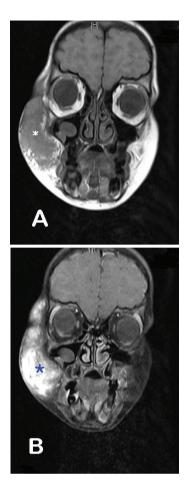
Magnetic resonance image of facial bones and neck: A)T1 prior to gadolinium administration. B)T2 after gadolinium administration with fat suppression. Mass is indicate (asterisk)
